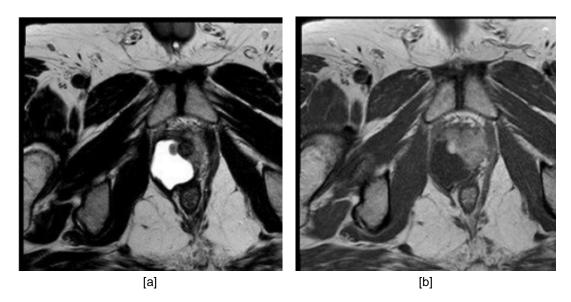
MRI: Post-operative images. Axial T2-weighted (a) and T1-weighted after administration (b) images persistence of synovial sarcoma in prostatic loggia.
